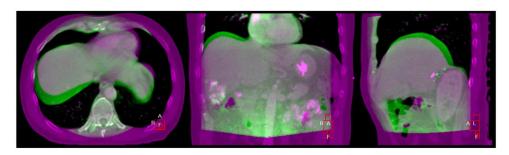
An example of a kV CBCT (obtained with 3 repeat breath holds) registered to the planning CT using the vertebral bodies. The baseline shift of the liver, relative to the bones, is evident by the purple (planning CT)/green (CBCT) color display.
